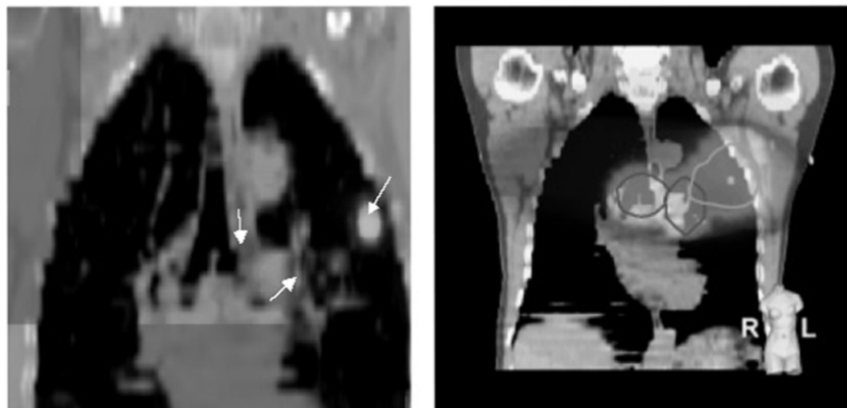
Left panel: matched positron emission tomography-computed tomography (PET-CT) scan of a patient with left upper lobe T2N2 non-small cell lung cancer (NSCLC). Arrows indicate foci of FDG uptake. Right panel: Dose distribution (coronal view) of the involved radiotherapy plan for this patient.
